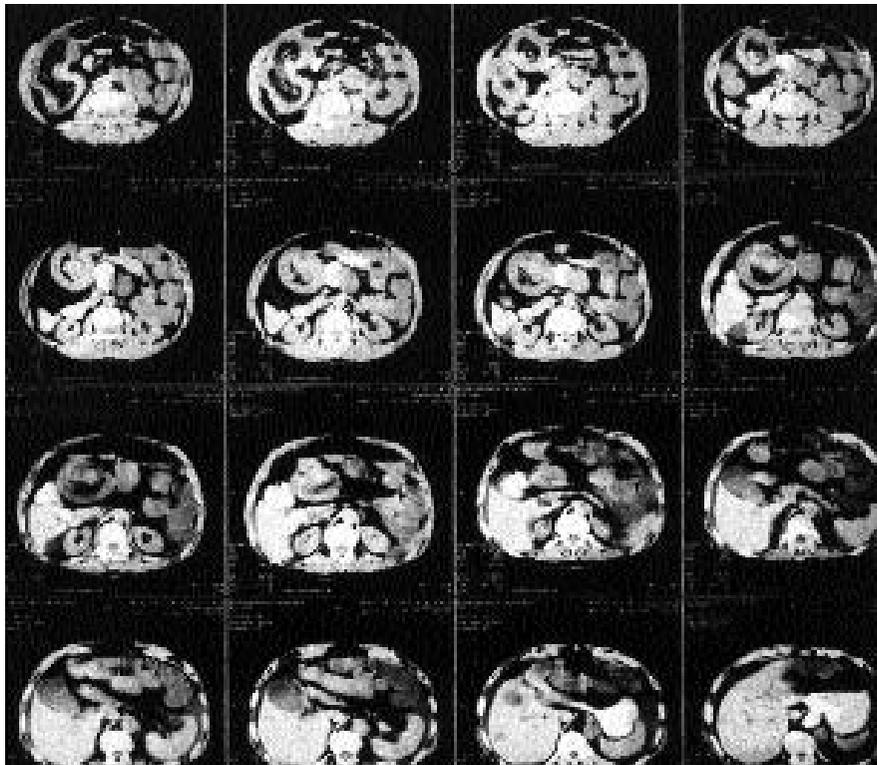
Intussusception appearance in the helical CT scan of the abdomen. The central mass represents the intussusceptum and the edematous intussusciens forms the external ring.
